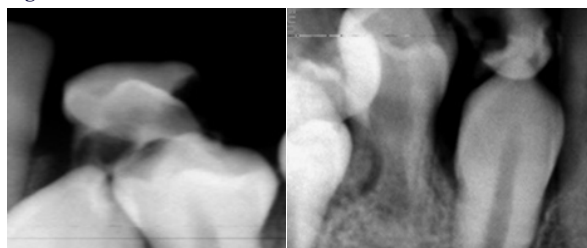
Intraoral Periapical Radiograph in relation with 84,83 and 74,73
